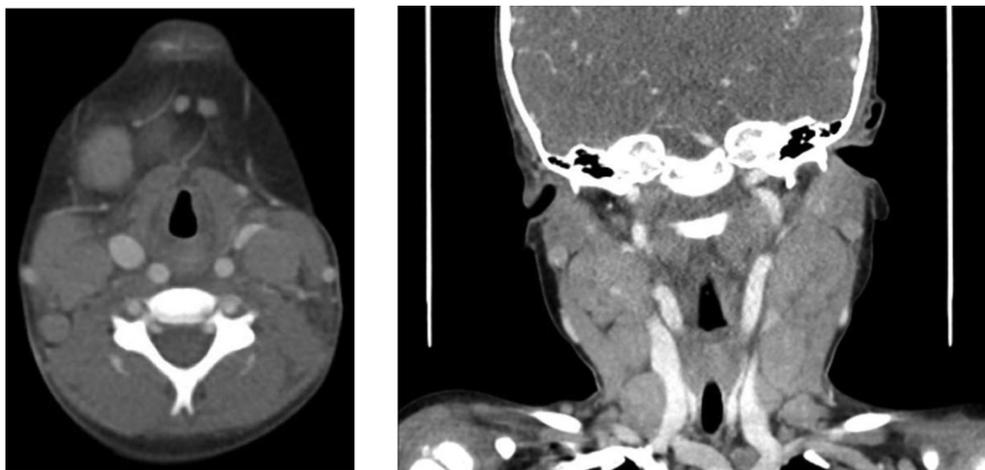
Axial and coronal computed tomography images revealing bilateral cervical lymphadenopathy compressing the internal jugular veins.
